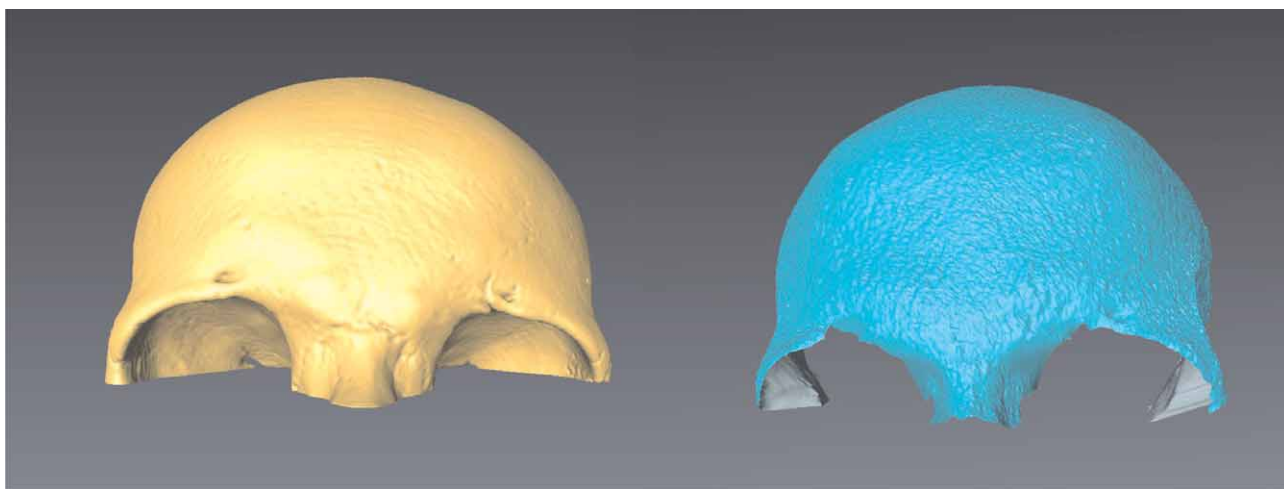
Frontal bone scanned by both methods, left CT derived model, right model from laser scanner.
